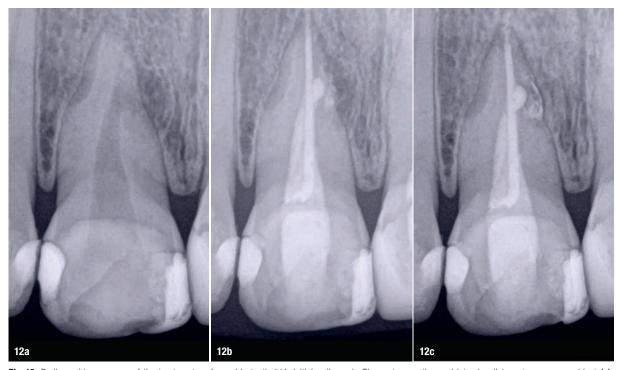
Radiographic sequence of the treatment performed in tooth #11. Initial radiograph. The root resorption and lateral radiolucent area were evident (a). Completed root canal therapy (b). Three-year follow-up radiograph showing complete healing of the lateral radicular radiolucent area and the correct sealing of the resorption (c).
